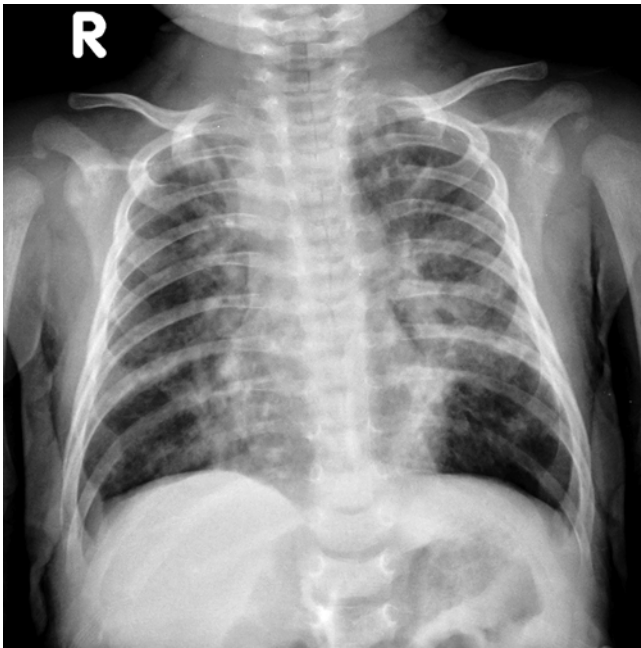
Chlamydia pneumonia* in a term infant. Anteroposterior chest radiograph at 6 weeks of age demonstrates bilateral diffuse interstitial infiltrates and hyperinflation. Typically, *Chlamydia pneumonia* develops between 2 weeks and 3 months of age and the imaging findings are worse than clinically anticipated
